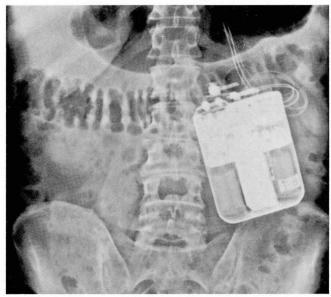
Radiographs of chest and abdomen showing placement of antitachycardia pacemaker and implantable defibrillator. Note large separation between AICD sensing electrodes in the left ventricle and the pacemaker lead in the right ventricular apex that minimizes potential for "crosstalk."
